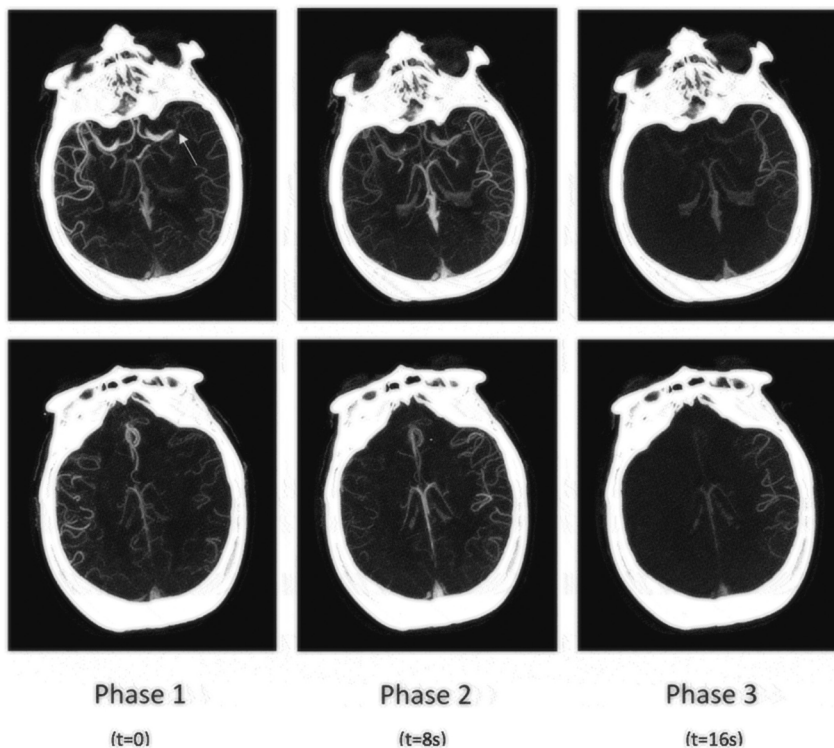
An example of multiphase CT angiography. Maximum intensity projection (MIP) images are shown (two levels). The patient has left middle cerebral artery (MCA) occlusion (arrow). Pial arterial filling is modest, with a delay of one phase when compared with the contralateral side.
